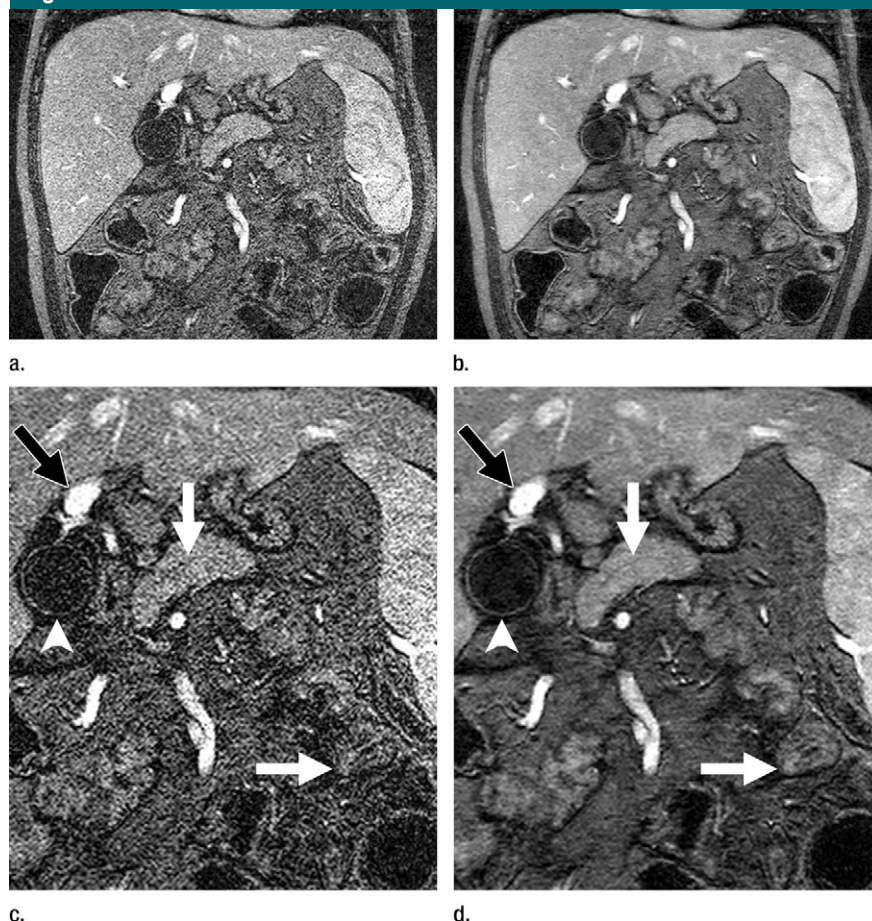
(a–d) Submillimeter near-isotropic-resolution contrast-enhanced T1-weighted MR images (repetition time msec/echo time msec, 4.7/1.4; section thickness, 2.2 mm; matrix, 384 × 384 over 30-cm FOV), with an acceleration factor of four, in 8-year-old boy. (a, c) Standard and (b, d) compressed sensing reconstruction images. (c, d) Zoomed images show improved delineation of the pancreatic duct (vertical arrow), bowel (horizontal arrow), and gallbladder wall (arrowhead), and equivalent definition of portal vein (black arrow) with L1 SPIR-iT reconstruction.
